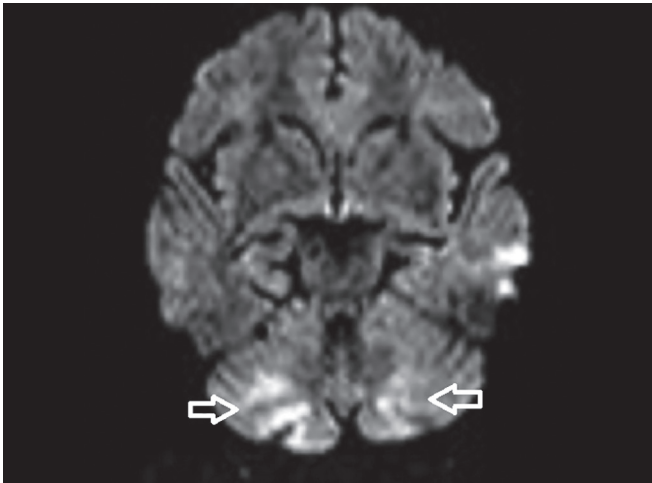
Magnetic resonance imaging brain showing hyperintensities in bilateral cerebellar regions on diffusion-weighted imaging suggestive of an acute cerebellar infarct
